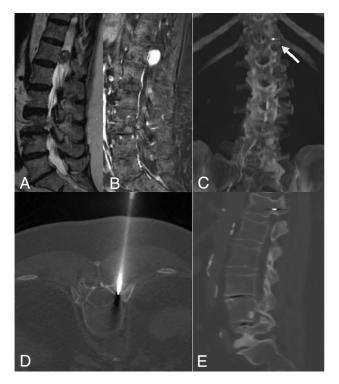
CT-guided gold fiducial marker placement. *A* and *B*, Sagittal T2WI and fat-saturated postcontrast T1WI demonstrate an intradural extramedullary, lobulated, homogeneously intensely enhancing mass that was resected and found to be a schwannoma on pathology. *D*, Intraprocedural axial CT bone windows at T12 demonstrate a coaxial bone access needle located within the left pedicle of T12. *C* and *E*, Postprocedural CT MIP and sagittal reconstructions confirm the gold fiducial marker placement in the left T12 pedicle. *Arrow* points toward gold fiducial marker.
